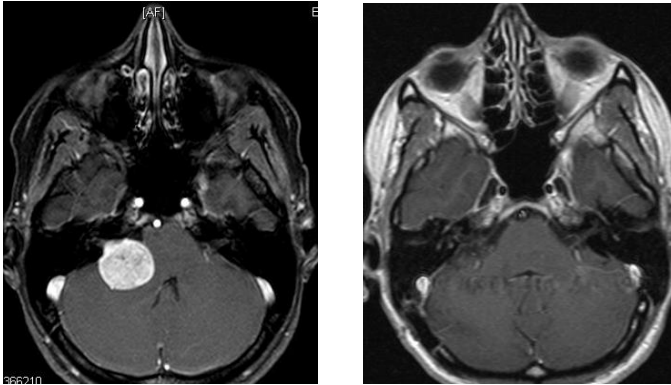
Sequential follow-up MR images showing transient early postradiosurgery tumor swelling of right Class T3a VS
